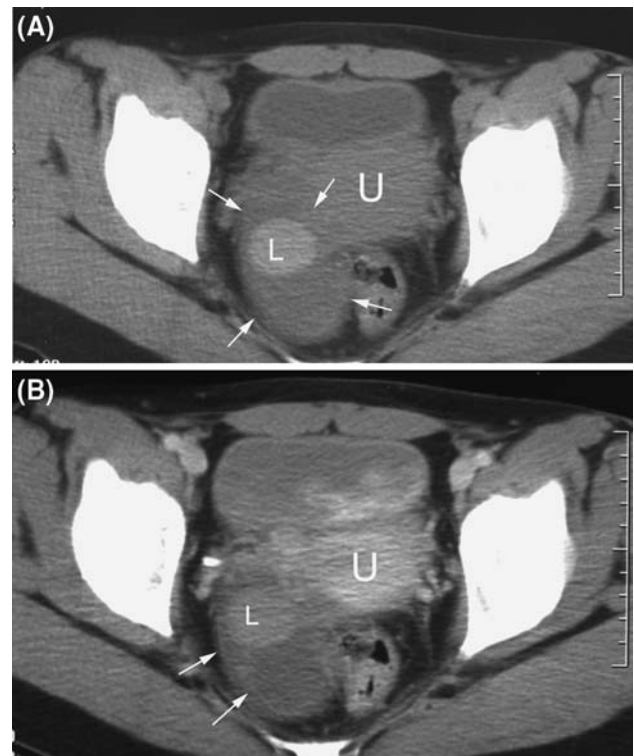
Struma ovarii in 24-year-old woman. A, Precontrast CT scan shows mainly cystic mass with a central high attenuation lesion (L) of 110.9 HU in the right ovary (*arrows*). Uterus (U). B, Contrast-enhanced CT scan shows moderate cyst wall enhancement (*arrows*), but the lesion is not significantly enhanced
